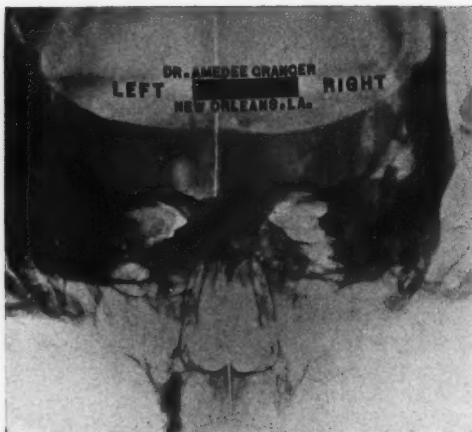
Roentgenograph of a skull with left sphenoid and the right frontal sinuses filled with plaster of Paris. The Granger line is invisible on the left and clearly visible on the right.
